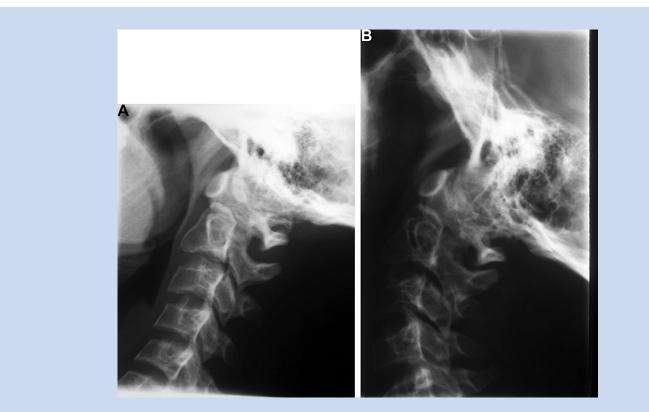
A: Lateral radiographs of the cervical spine in flexion of patient 98 with SEDC due to the p.Gly351Val mutation at adult age. Note the severe dens hypoplasia. B: Lateral radiographs of the cervical spine in extension of patient 98. Note minimal posterior movement of C2 in relation to C1 (less than 5 mm, no atlanto-axial instability).
